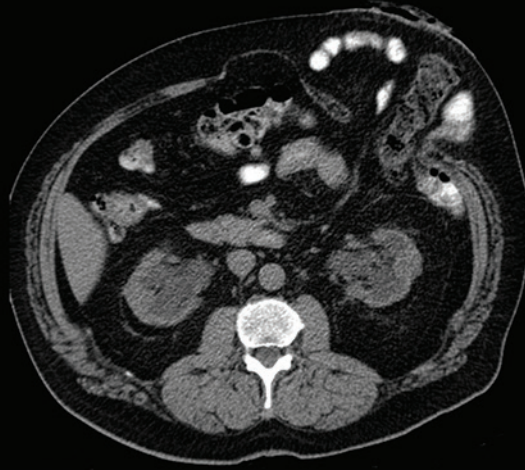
CT-scan displaying a combination of IH and PH
